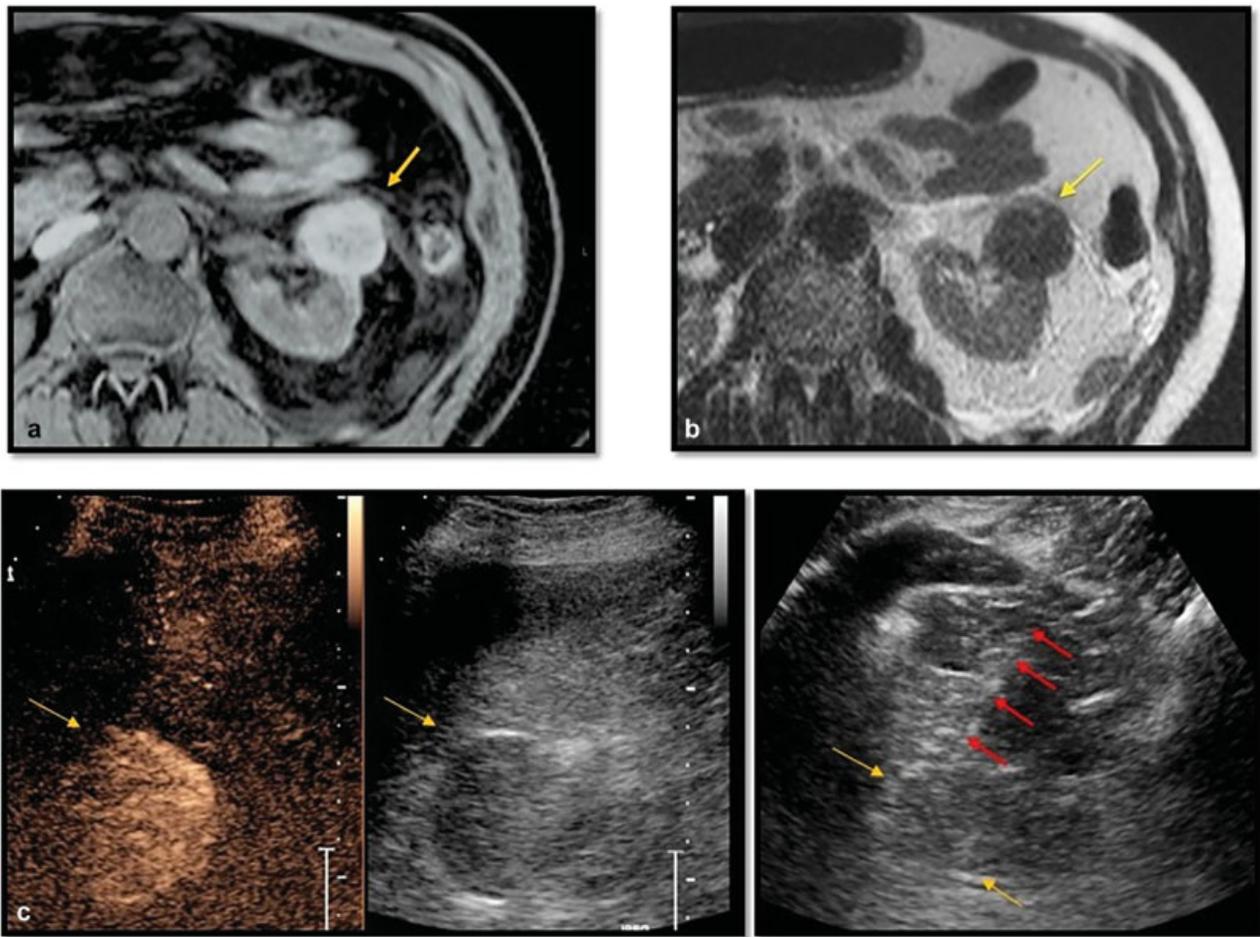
Percutaneous microwave ablation of a 62-year-old man with 4-cm clear cell renal cell carcinoma partially exophytic (yellow arrow) on axial T1, T2-weighted MRI after ablation (a, b). Contrast-enhanced ultrasound during procedure helped to visualize lesion margins and guide more precise placement of microwave antenna (red arrow; c).
